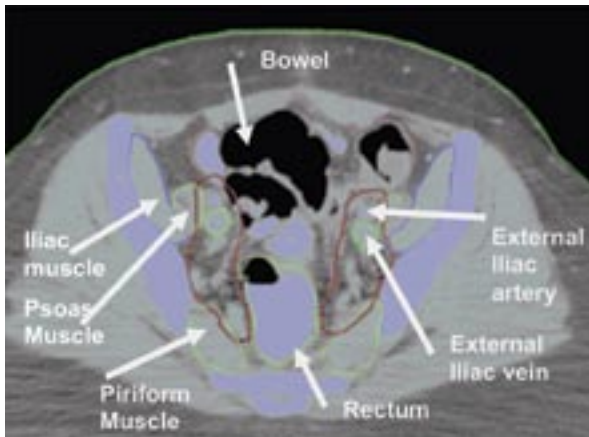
Axial computed tomography (CT) slice through the mid-pelvis in an endometrial cancer patient treated with intensity-modulated pelvic radiation therapy. The clinical target volume (CTV) (red) encompasses the internal and external iliac lymph node regions. Highlighted are various pelvic muscles that are used to help define the limits of the CTV. Normal tissues are also contoured and are used as avoidance structures in the planning process.
